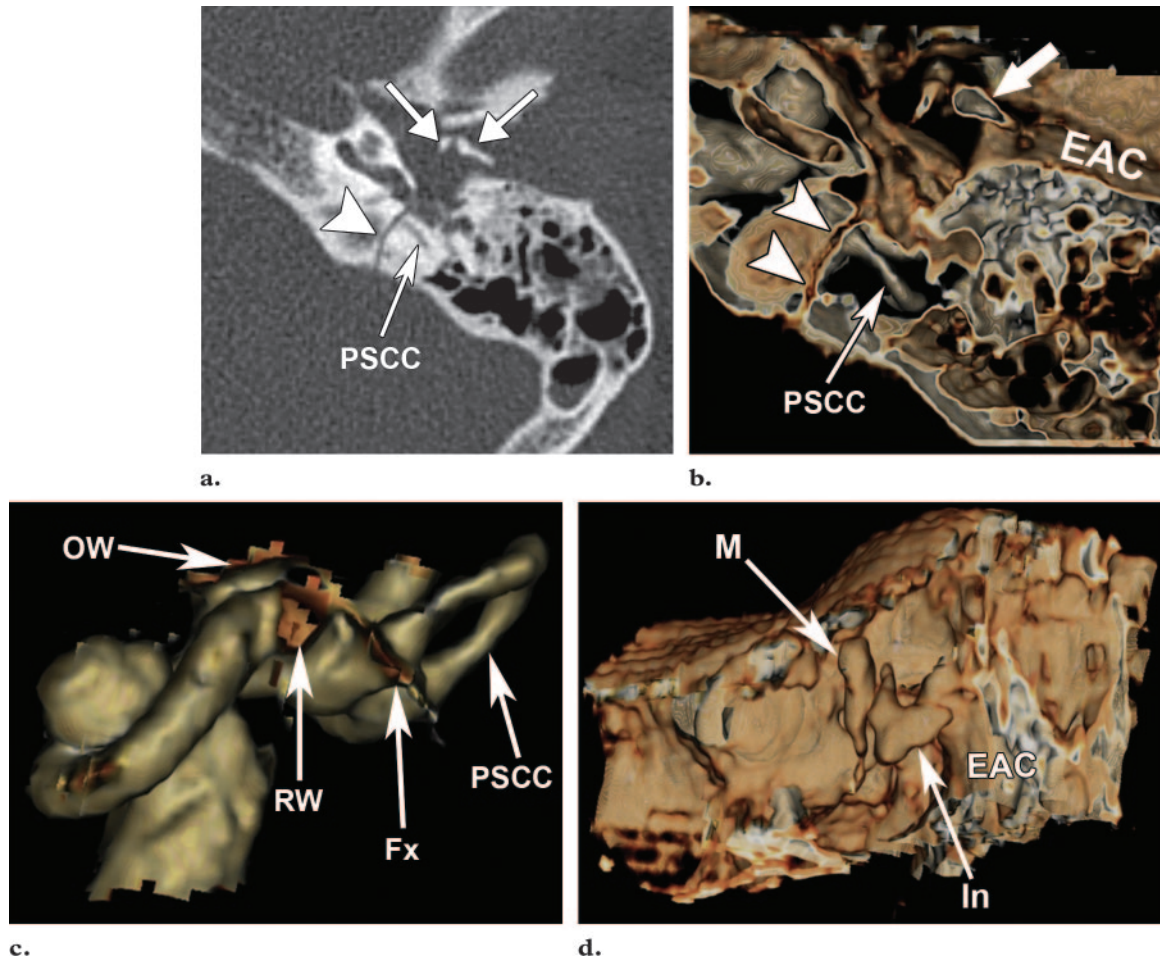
Temporal bone fracture caused by trauma in a 51-year-old man. (a) CT scan shows a fracture (arrowhead) through the posterior semicircular canal (*PSCC*) extending to involve the ossicles (arrows). (b) Corresponding 3D CT reformatted image also demonstrates the fracture (arrowheads) through the base of the posterior semicircular canal (*PSCC*) extending to the ossicles. The ossicles appear to have an abnormal configuration, suggesting possible dislocation of one of the ossicles (arrow) into the external auditory canal (*EAC*). (c) Three-dimensional VR CT image (posteroinferior view) shows the fractured bony labyrinth, with the fracture line (*Fx*) extending through the base of the posterior semicircular canal (*PSCC*) into the round window (*RW*) and oval window (*OW*). (d) Three-dimensional VR CT image (anterior view after dissection of the anterior wall of the *EAC*) shows incudomalleolar disarticulation, with the incus (*In*) located lateral to the malleus (*M*) and partly within the external auditory canal (*EAC*).
